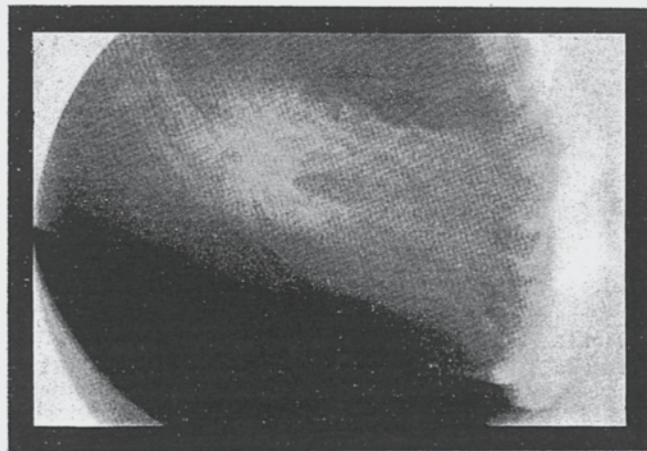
Même malade. La radiographie de contact confirme l'image de la radiographie standard et permet de faire le diagnostic de tumeur maligne.
